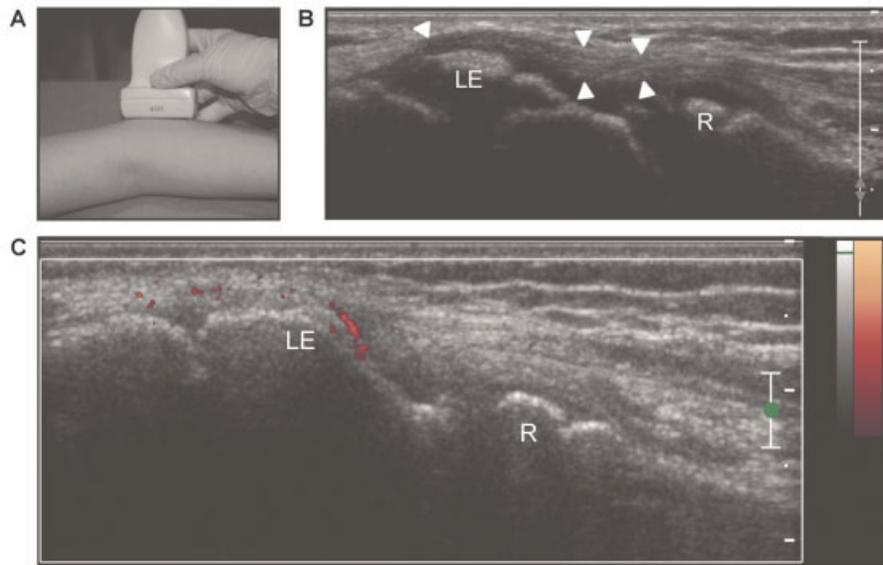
Ultrasound examination of the common extensor tendon insertion at the lateral elbow using a Philips IU22 machine with a high-frequency linear-array 12-MHz transducer. Power Doppler imaging was performed in long and transverse planes. A, Images were acquired with the elbow in mild flexion and the forearm pronated. B, An image from the gray-scale evaluation shows the thickness of the tendon, as delineated by the arrowheads. LE = lateral epicondyle; R = radial head. C, An image from the Doppler evaluation shows moderate vascularization. Red regions are increased power Doppler signals, which indicate increased vascularity.
